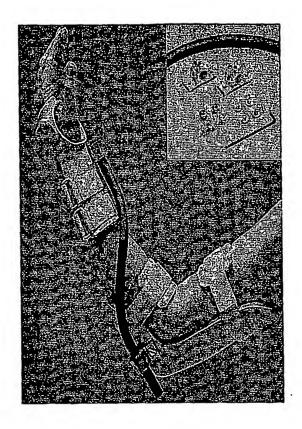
Radiographic positioning. Subject is positioned with arm abducted to 90° and elbow flexed at 90° (the standard variance position). Three forearm rotation conditions were filmed utilizing the wrist variance position. A fourth radiograph was taken with the elbow fully extended and the humerus internally rotated. Here she is shown maximally positioning the forearm in supination. Films were also taken, not shown here, in the neutral position, in a passive supinated position while wearing the splint with elbow bent, and passive supinated position while wearing the splint with elbow extended.
